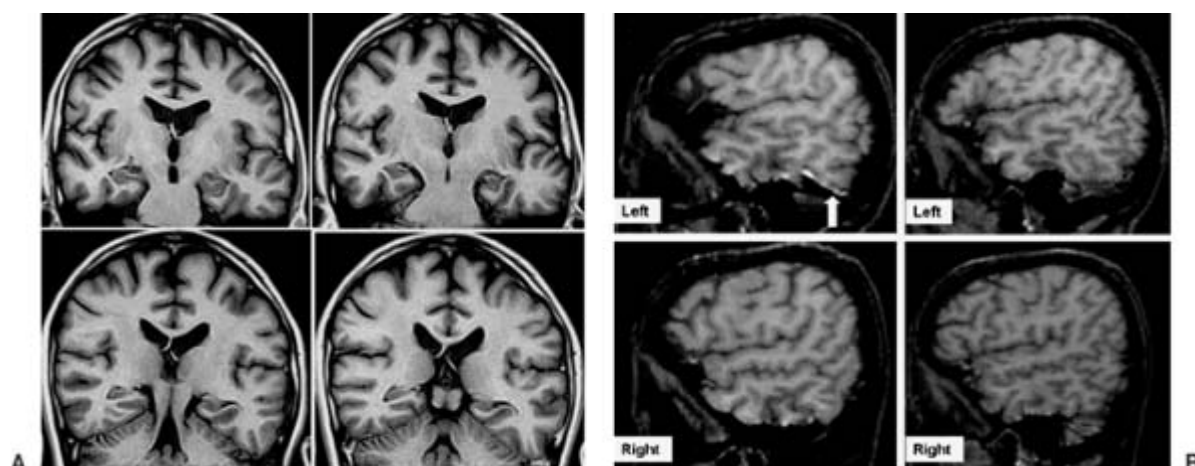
A: T1-IR coronal images from a patient with *LGI-1* mutation showing left temporal lobe dysgenesis, characterized by enlargement of the lateral temporal lobe, with small gyri (although not characterizing polymicrogyria). B: T1 sagittal images from the same patient showing absence of first and second temporal sulcus on the anterior and middle portions of the left temporal lobe. The posterior basolateral aspect of the left temporal lobe is also abnormal, with a protrusion of parenchyma downward, with an “encephalocele-like” appearance (*arrow*). (Reproduced, with permission, from Kobayashi E, Santos NF, Torres FR, et al. Magnetic resonance imaging abnormalities in familial temporal lobe epilepsy with auditory auras. *Arch Neurol.* 2003;60(11):1546-1551. Copyright © 2002, American Medical Association. All rights reserved.)
